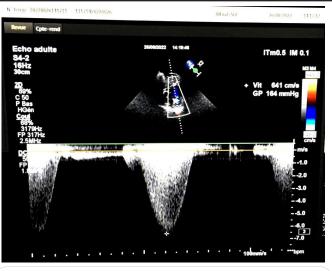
Echocardiography, pressure in the upstream chamber, estimated in continuous doppler at 160 mmHg peak.
